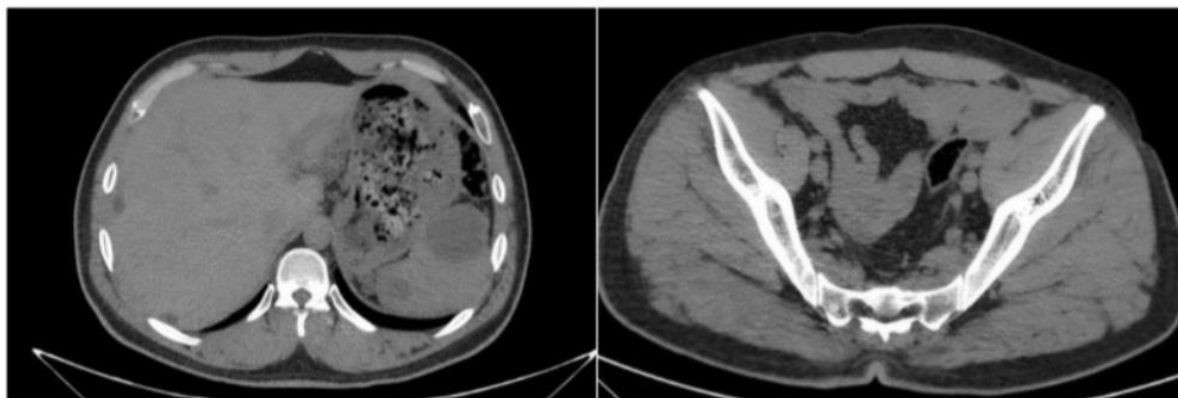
Follow-up abdominal CT scan demonstrating marked reduction in peritoneal cystic lesions
